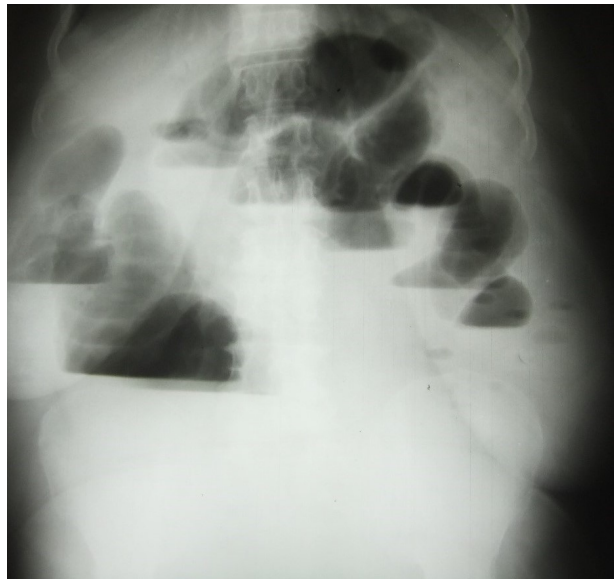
Hydroaeric levels of colonic type on abdominal x-ray.
